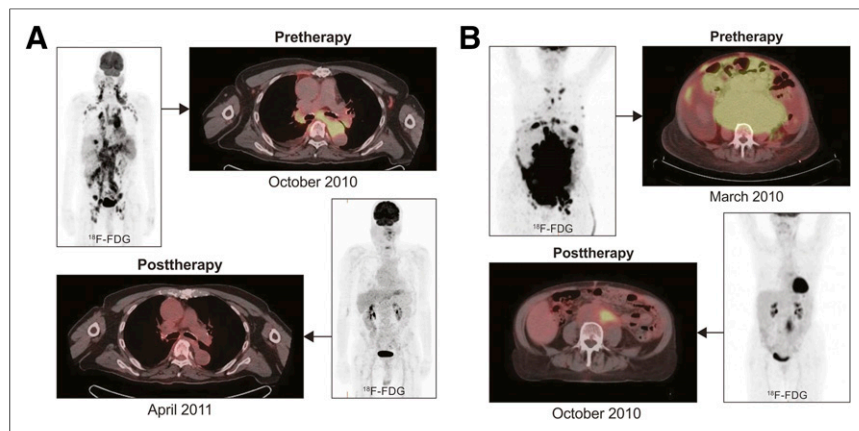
(A) Pretherapy and posttherapy ¹⁸F-FDG PET/CT scans for patients showing a CMR to BR. (B) Pretherapy and posttherapy scans for patients without CMR (partial response) after BR.
